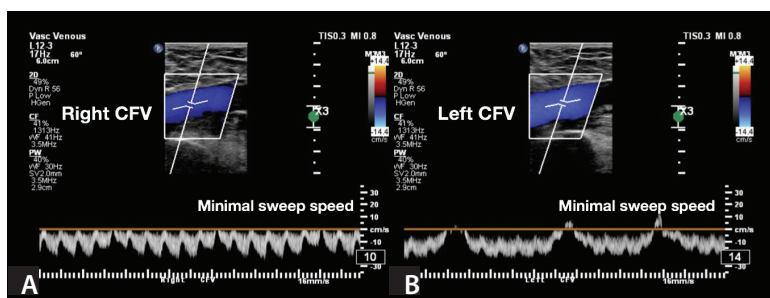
A 62-year-old woman presented with bilateral advanced venous disease. Asymmetric CFV pulse Doppler waveforms acquired during routine chronic venous insufficiency exam noted phasic flow bilaterally; however, the waveform contour was completely different between the right (A) and left (B) sides. Iliocaval duplex evaluation demonstrated significant bilateral compression by the overlying artery.
